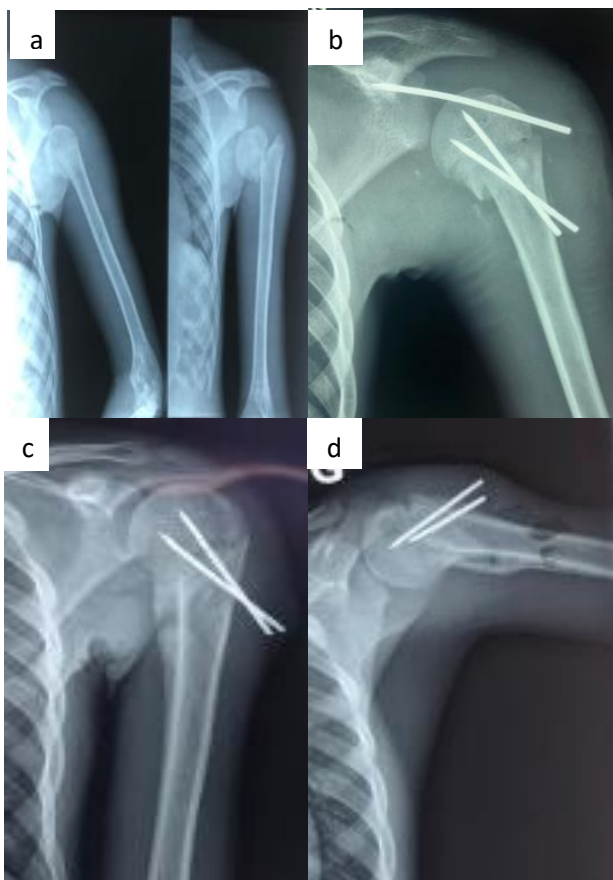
Radiographic aspects of (a) a simultaneous anterior shoulder dislocation and salter and Harris type 2 fracture of the proximal humerus; (b) dislocation reduction, Kirschner wire fixation of the fracture and the glenohumeral joint; (c, d) Glenohumeral Kirschner wire removal with bone union.
